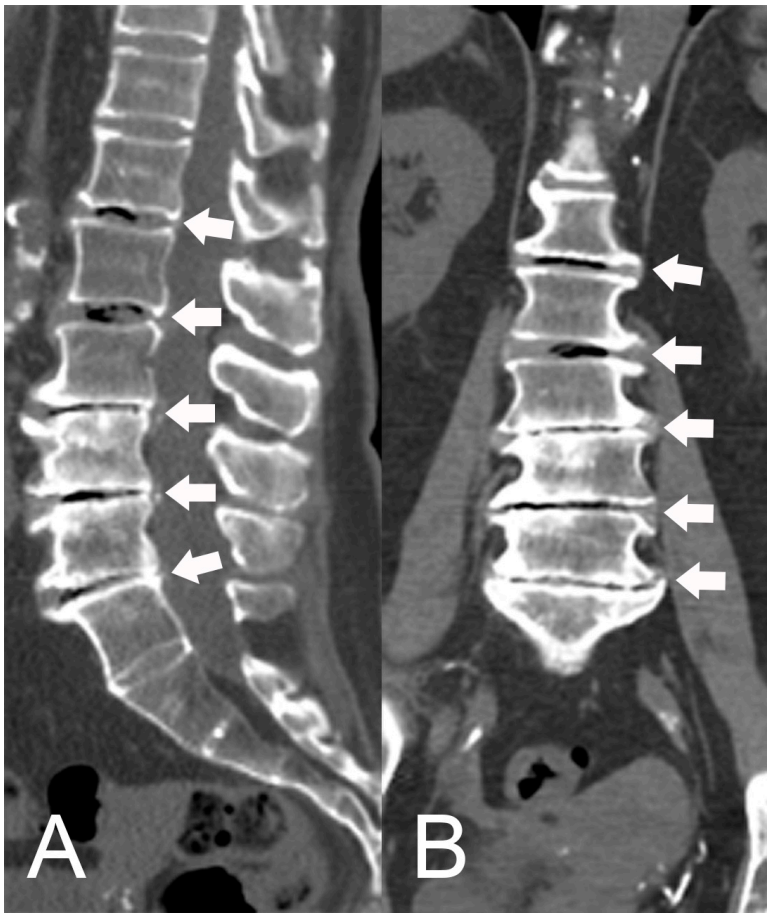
Abdominal CT reconstructions in sagittal (A) and coronal (B) planes of an 81-year-old woman. The arrows indicate the area of translucency in all intervertebral disks from L1 to S1 vertebrae, consistent with the vacuum phenomenon.
